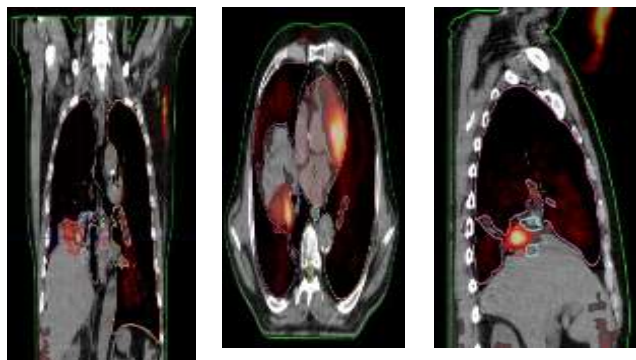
Lung cancer in different Views for CT fusion with PET/CT.
